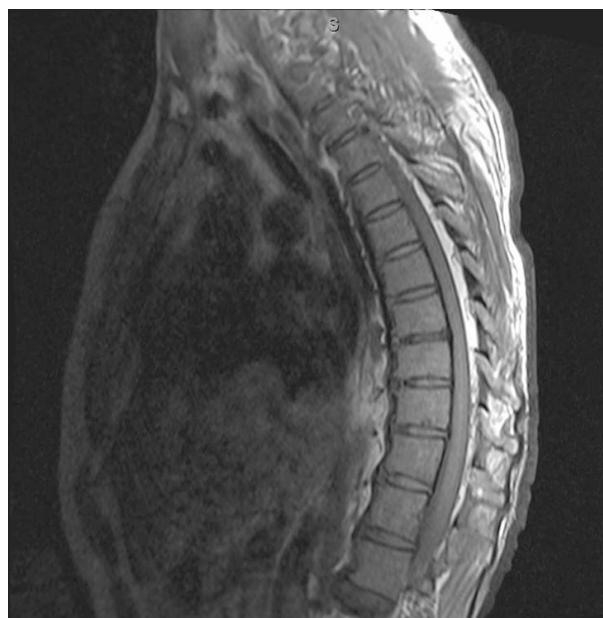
Prevertebral abscess on T1 post-contrast magnetic resonance imaging (Sagittal View).
